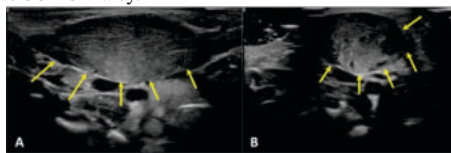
Images A (longitudinal), Image B (Axial) shows ultrasound examination of the neck reveals a well-defined, ovoid, hypoechoic mass within the sternocleidomastoid muscle, typically located in the middle portion of the muscle. The lesion is characterized by homogeneous echotexture, with loss of normal striated architecture of muscle (Yellow arrows). The mass demonstrates mild posterior acoustic enhancement, resulting in increased echogenicity of structures deeper to it. There is no evidence of calcifications or necrosis within the mass. The surrounding tissues appear normal, without signs of infiltration or distortion. These findings are consistent with fibromatosis colli, a benign self-limiting condition commonly seen in infants
